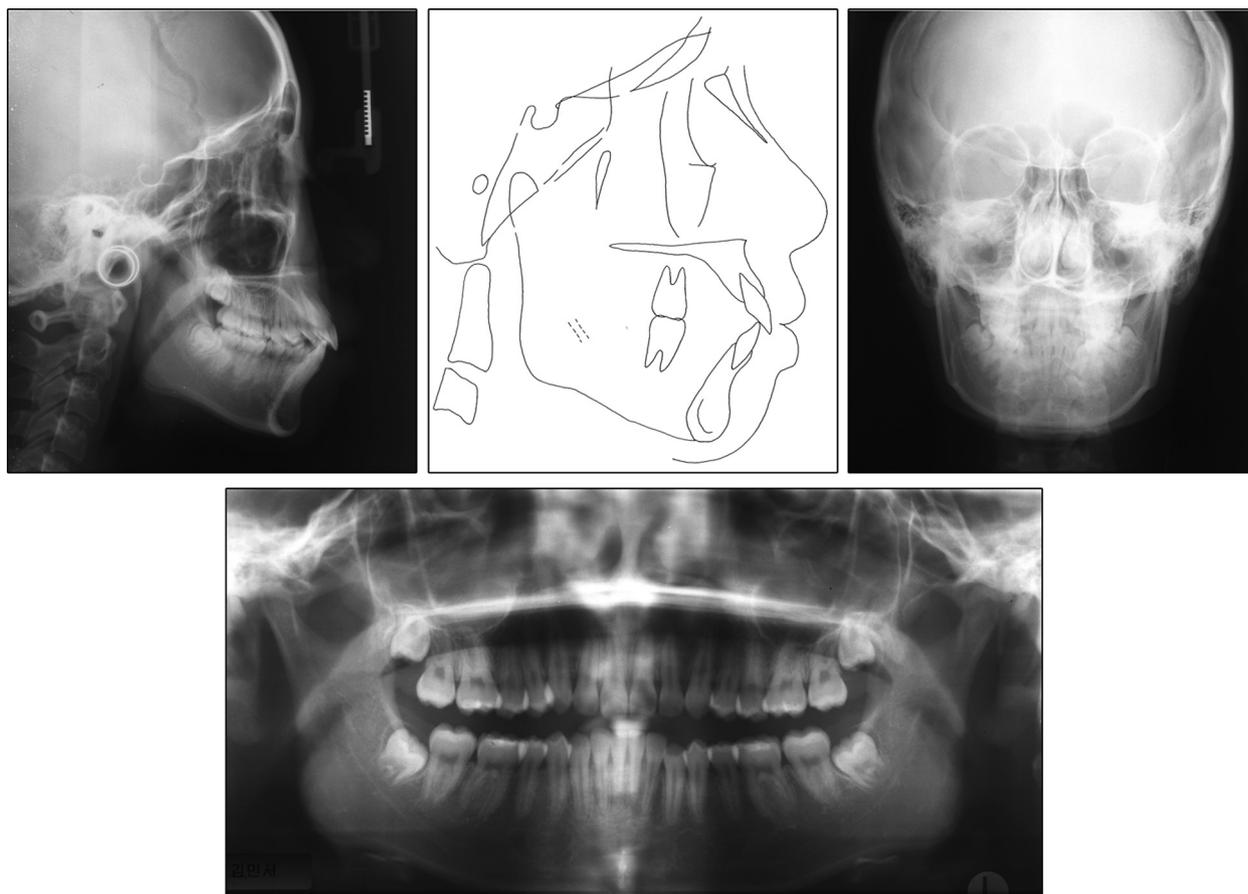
Pretreatment radiographs and tracing.
